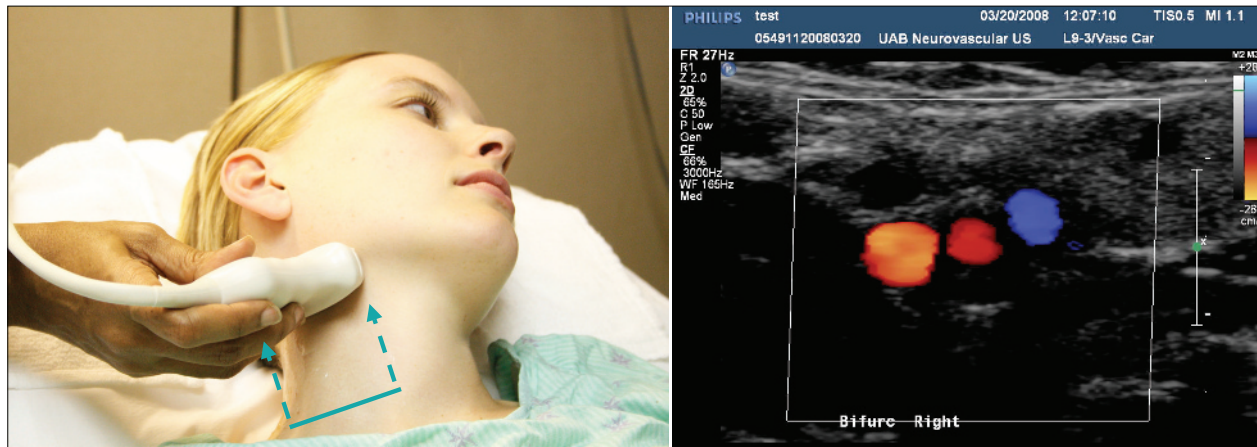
Transverse positioning of the duplex transducer depicts carotid bifurcation on the neck. Arrows indicate a proximal initial placement of the probe and its ascent to the bifurcation as the initial step to extracranial vascular examination. The left side of the ultrasound B-mode and color flow image is oriented towards the midline. Red color shows arterial flows, blue indicates the jugular vein.
